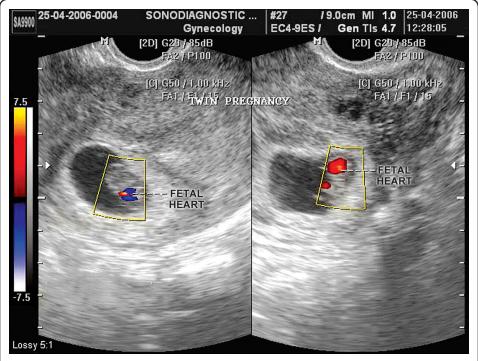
Color Doppler scan (TVS) showing twin pregnancy with cardiac activity of both the fetuses [*By courtesy:* Prof. BN Chakravorty and Dr (Mrs) S Ghosh, IRM, Calcutta]
